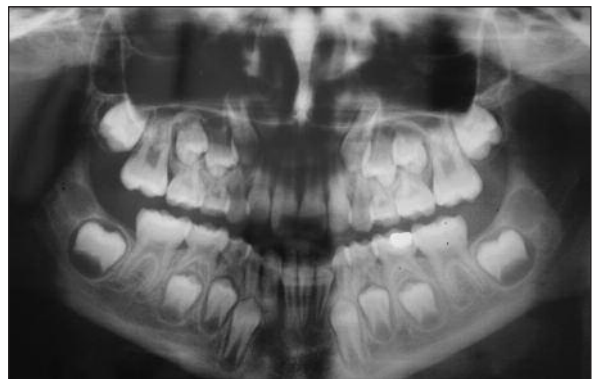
Panoramic radiography shows severe bone loss around maxillary incisors.
